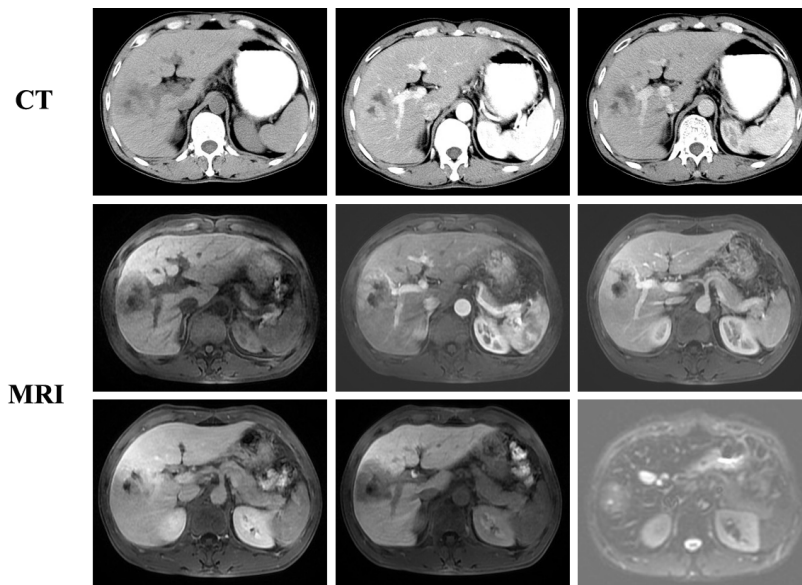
Preoperative CT (A) and MRI (B) of the liver.
